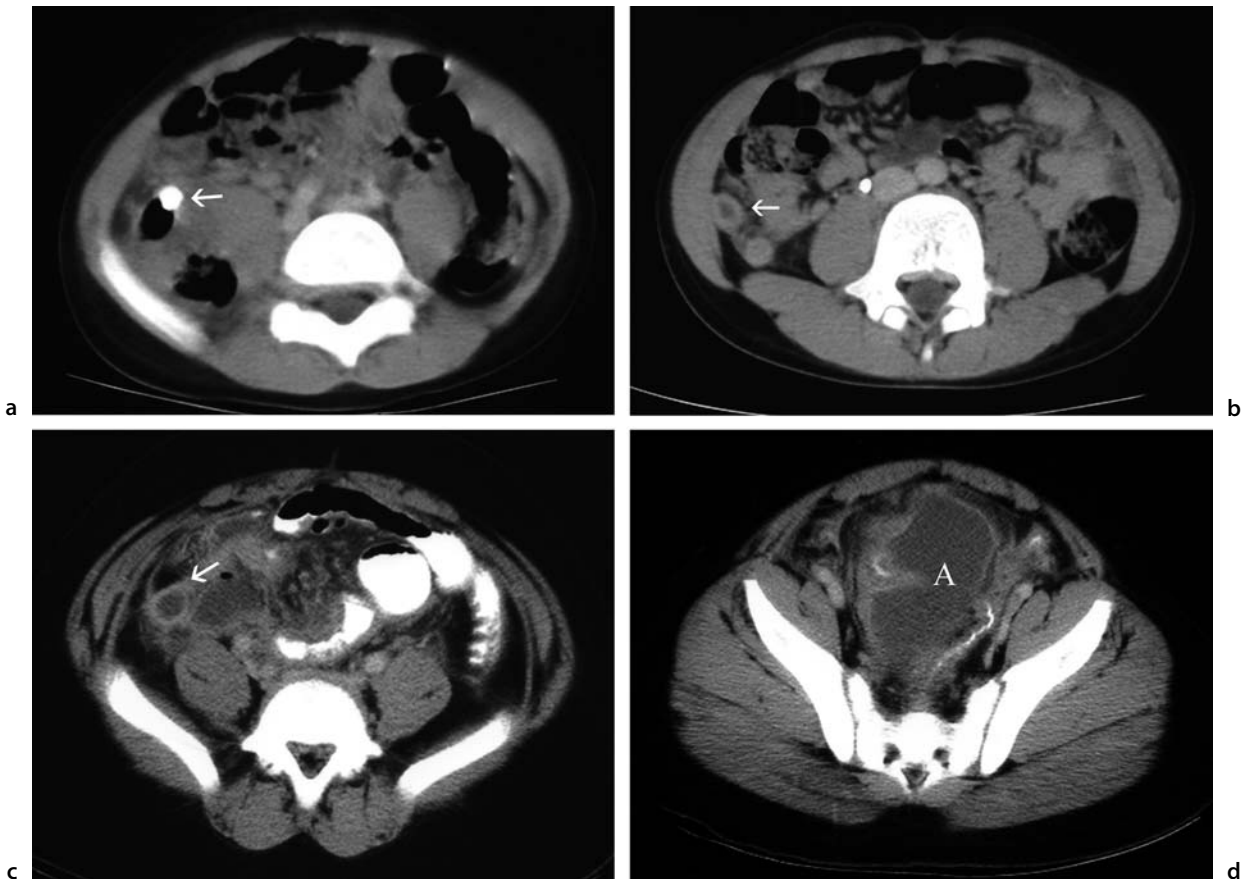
CT of appendicitis
